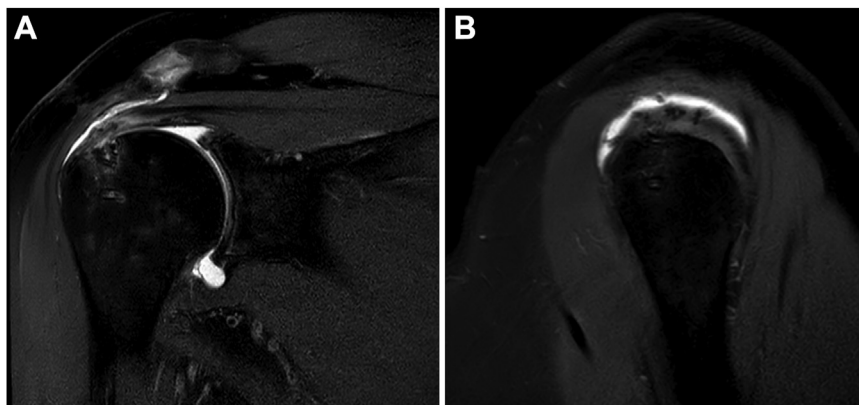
Arthro-MRI (coronal (A), parasagittal (B) plane) T2-weighted, 6 months post arthroscopic rotator cuff repair. *Arthro-MRI*, magnetic resonance arthrography.
